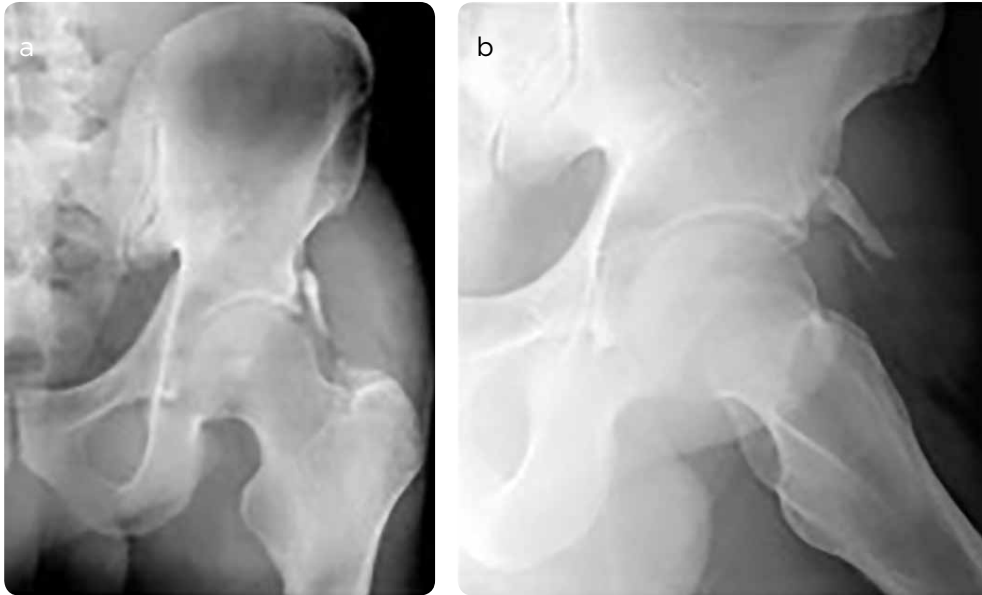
X-ray of the left hip, projections a) anteroposterior and b) lateral. In the soft tissues adjacent to the outer edge of the acetabular roof, two calcified linear images with phalanx-like morphology corresponding to pelvic fingers are identified.
